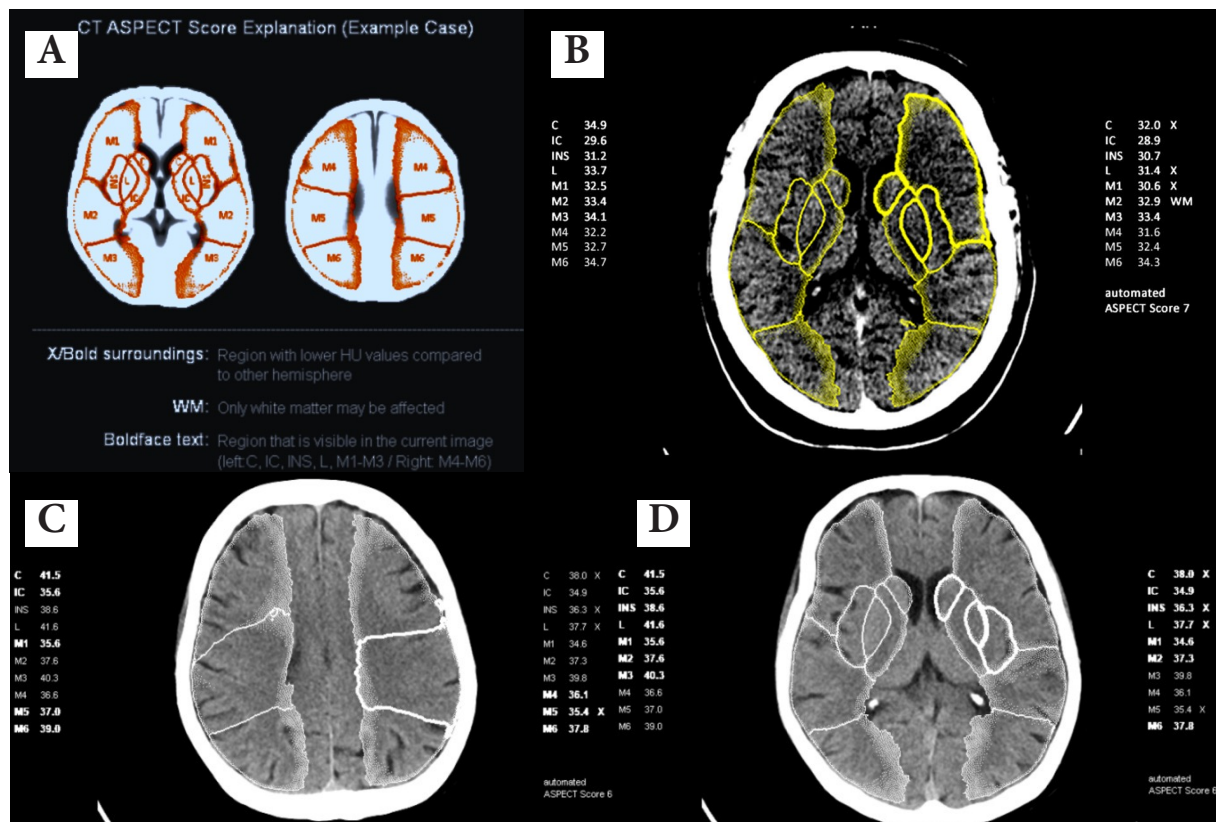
(A) Example of CT-ASPECT score explanation in the automated software, showing the outlines of ten ASPECTS regions as an overlay on the axial NCCT images based on a quantitative topographic comparison of the left and right hemispheres. (B) Example of axial NCCT images with automatically computed EIC regions calculated with automatic software; the affected hemisphere is automatically selected by the software on the left side. The three affected regions are marked with X. Bold text indicates regions that are visible in the slice image (both hemispheres). Regions marked with WM, white matter, may be affected (are not used to calculate the ASPECTS). The automatically calculated ASPECTS (below the affected hemisphere) was 7. (C and D) Axial NCCT images of the same patient show areas with automatically calculated EIC, visualized within an overlaid white line using automated software. Bold text indicates regions visible in the different slices (both hemispheres). The automatically calculated ASPECTS was 6 in the left cerebral hemisphere. ASPECT scores were based on standard NCCT in the Picture Archiving and Communication System.
